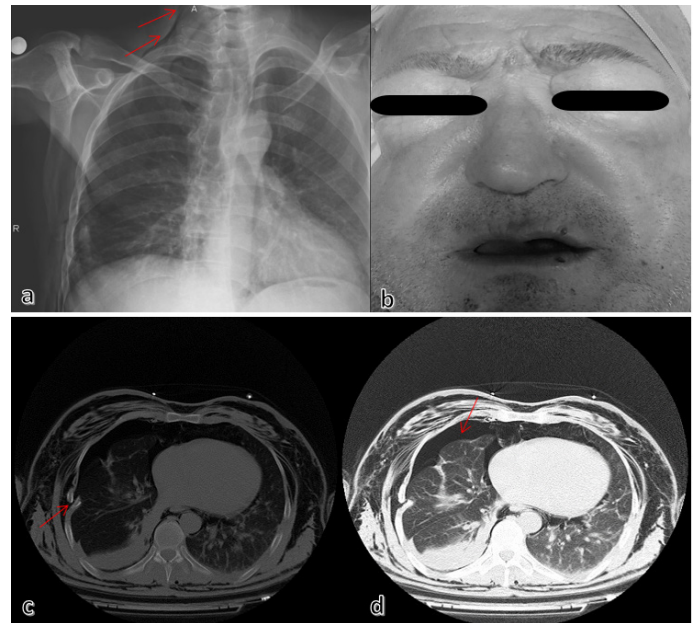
A. Chest radiograph at initial presentation B. Image of edema on the face of a patient who cannot open his eyes spontaneously C. Traumatic rib fracture (red arrow) D. Traumatic pneumothorax (red arrow)
